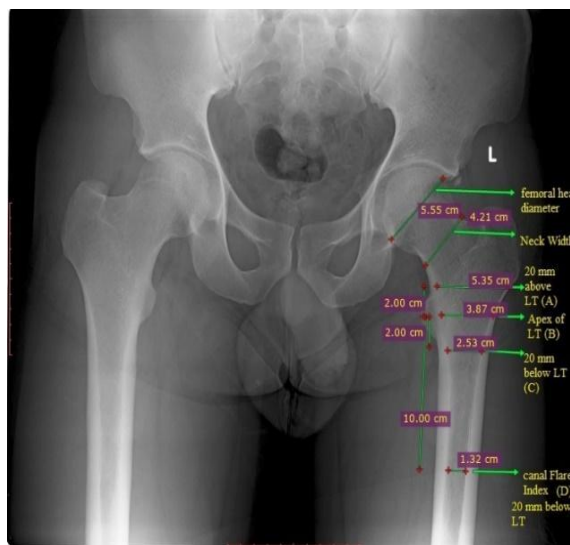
Sagittal X-ray of Hip showing femoral head diameter, Neck Width, Medullary canal diameter, Canal Flare Index
